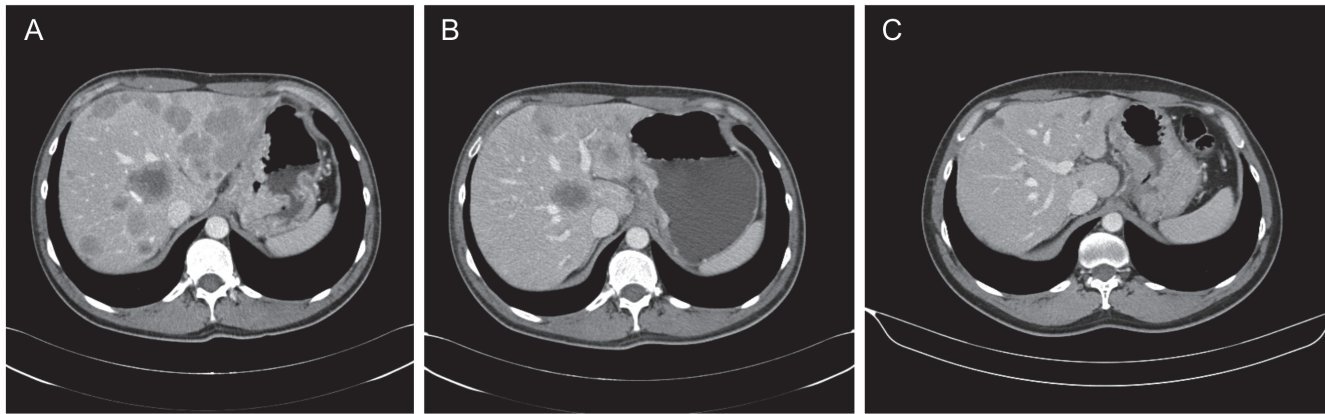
Computed tomography scans (A) at May 2013 (baseline), (B) at August 2013 (after six cycles) and (C) at December 2013 (after twelve cycles).
